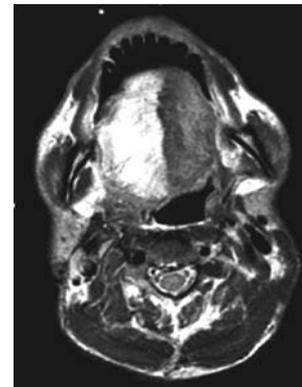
Axial cut, T2 weighted MRI at the mandible level.
